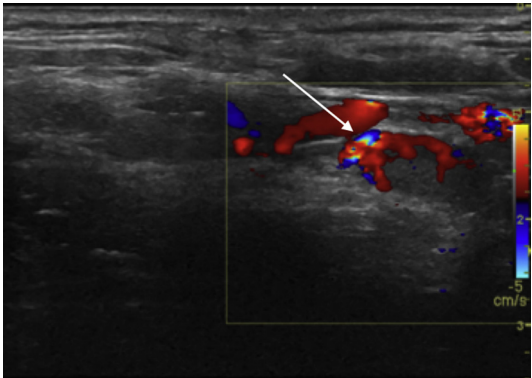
Color Doppler sagittal ultrasound image demonstrating an ovoid soft tissue nodule, which is slightly hypoechoic to the adjacent thyroid gland (not shown). The peripheral flow emanating from a feeding vessel at the superior pole of this nodule (arrow) is the typical sonographic appearance of a parathyroid gland.
